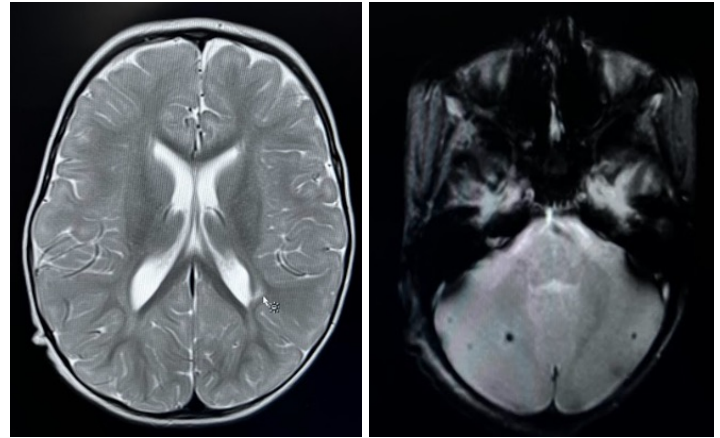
/2: MRI Brain with Sedation
